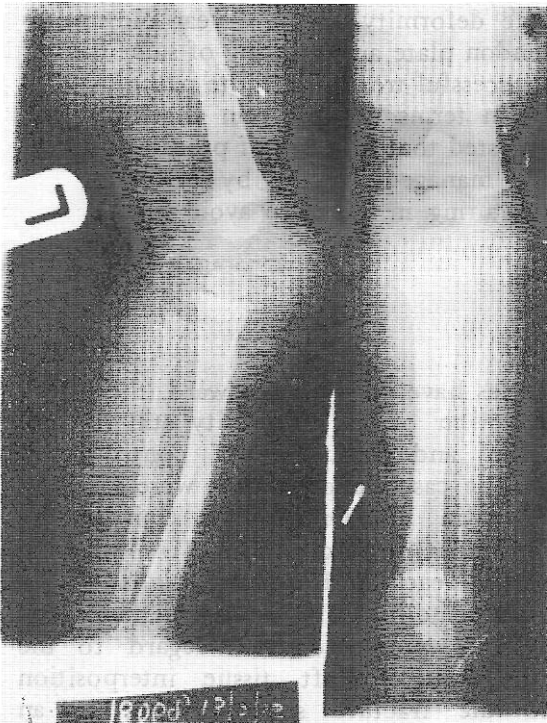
X-ray of the original metaphyseal fracture of the left proximal tibia at the age of one. (Case I).
